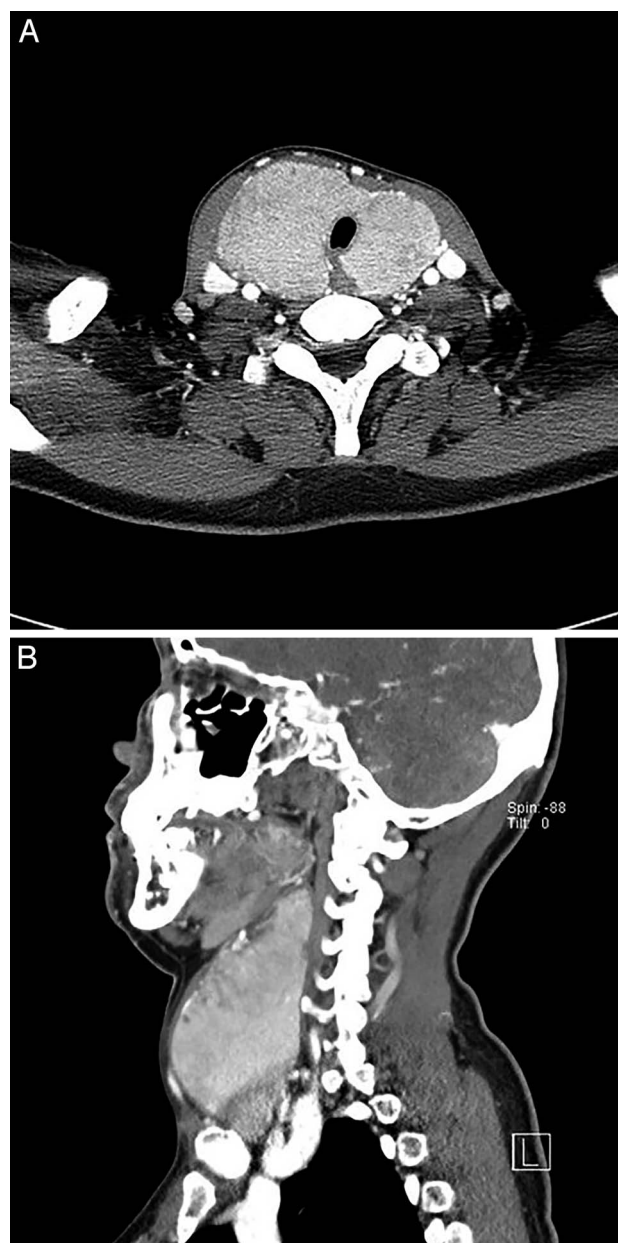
Cervical computed tomography of our patient, showing (A) enlargement of the thyroid gland with increased dimensions, resulting in a mass effect on the trachea, and (B) extension to the level of the submandibular gland.
